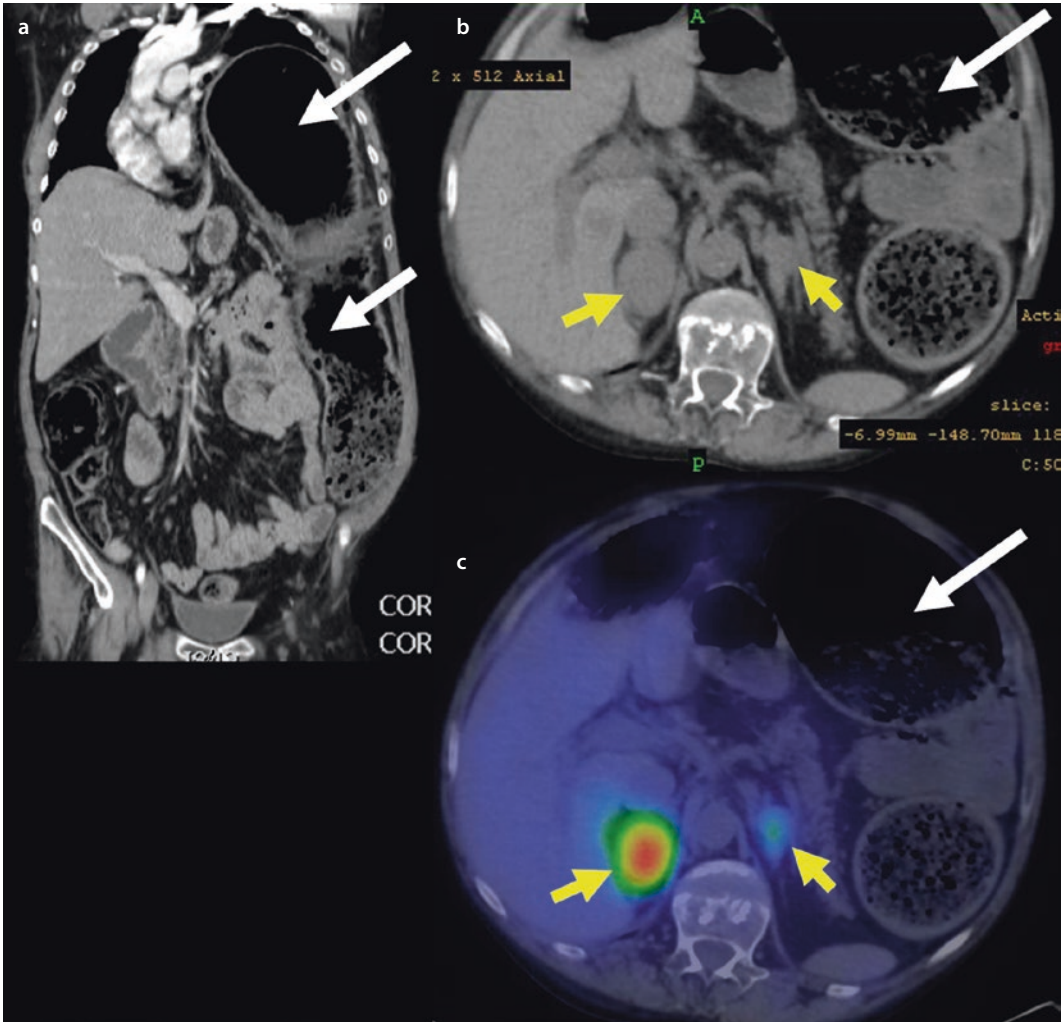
a Megacolon due to obstruction caused by intestinal ganglioneuromatosis in a MEN2B patient (white arrows), coronal CT picture. A part of the megacolon is herniated to the thorax. b Axial CT-imaging of a bilateral pheochromocytoma in MEN2B (yellow
